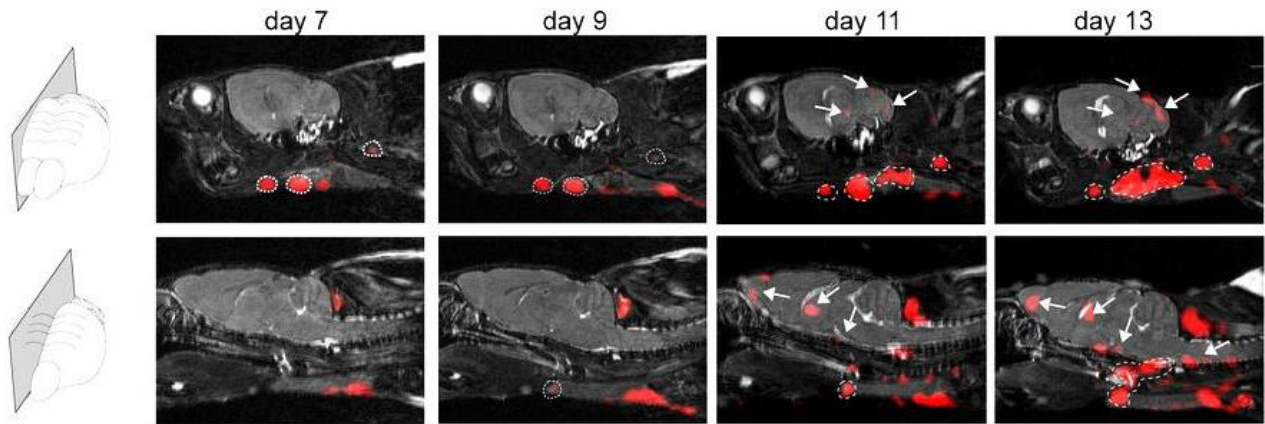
Visualization of inflammation in different CNS and lymphatic regions using *in vivo* ¹⁹F/¹H MRI. Two different sagittal slices of a 3D Turbo RARE-scan show the kinetics of inflammatory cell migration (¹⁹F MRI) over a period of 6 days in different CNS and lymphatic regions (¹H MRI).
